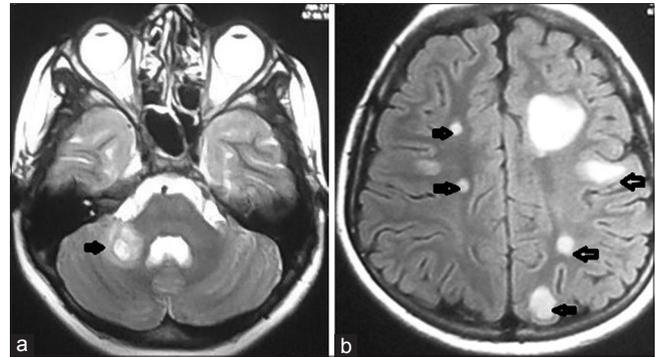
(a and b) Repeat magnetic resonance imaging at second visit showing new lesions of similar morphology in bilateral frontoparietal periventricular white matter, right brachium pontis extending to superior cerebellum showing irregular peripheral enhancement (marked by arrows)
